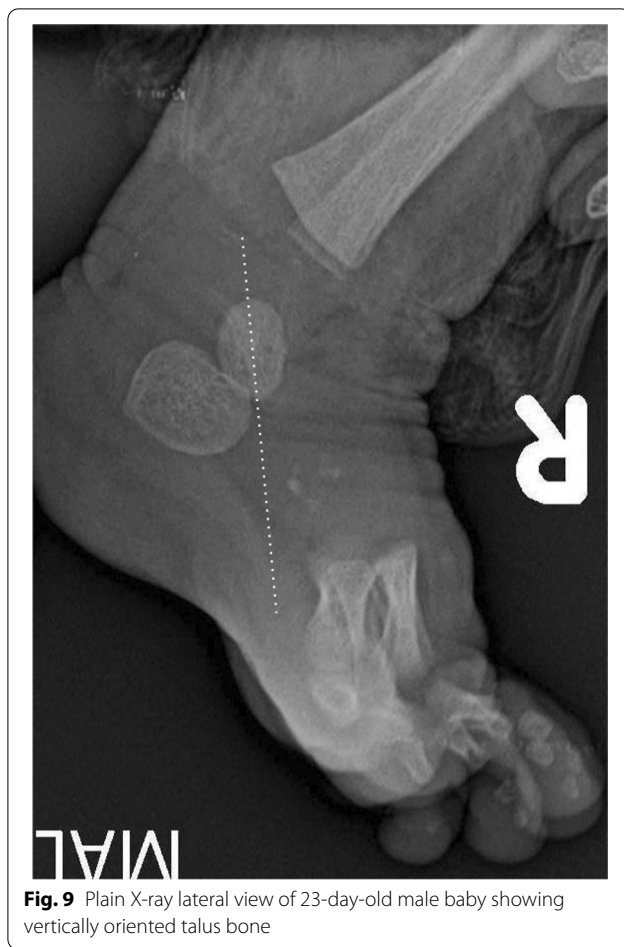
Plain X-ray lateral view of 23-day-old male baby showing vertically oriented talus bone
